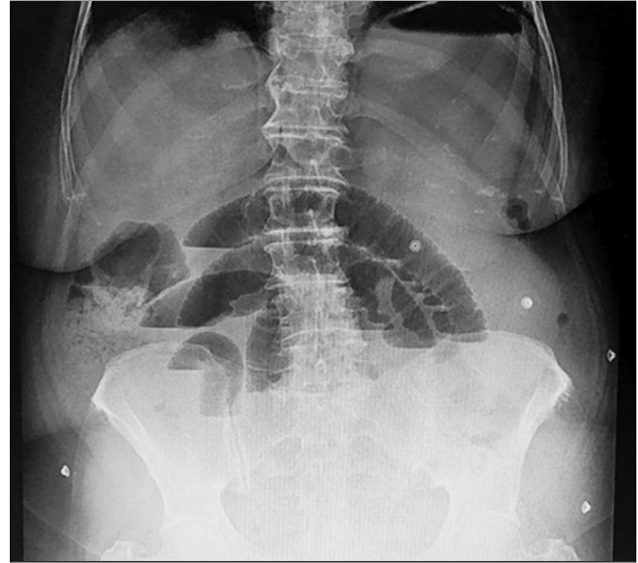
Plain abdominal x-ray showing intestinal air-fluid levels.
